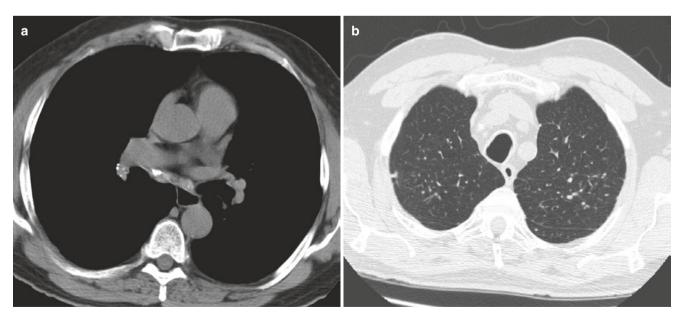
Early simple silicosis. (a, b) Axial CT images show upper lung predominant tiny nodules in upper lungs with fine septal thickening and punctate and amorphous calcification in mediastinal and hilar lymph nodes
